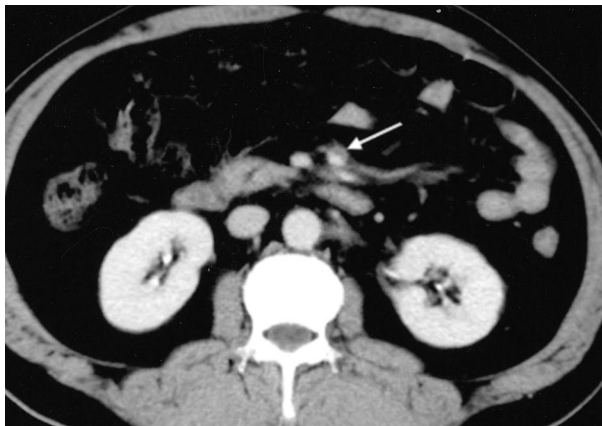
Spiral computed tomography image showing segmental low density in the superior mesenteric artery.
